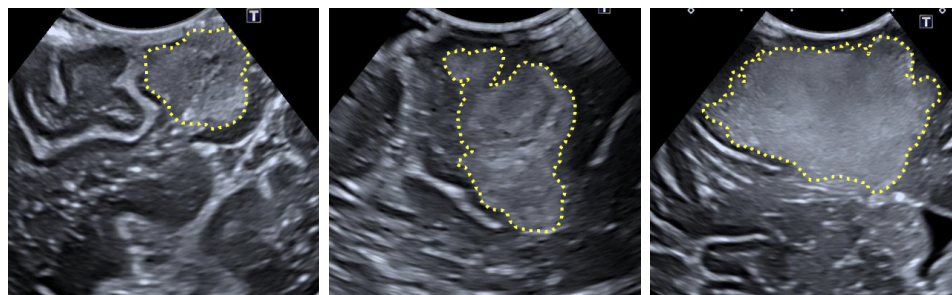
Human intraoperative ultrasound images of Glioblastoma. The tumours are highlighted using the yellow dotted lines. The left and right figures show a maximum depth of 5cm, while the middle figure shows a maximum depth of 4.5cm.
